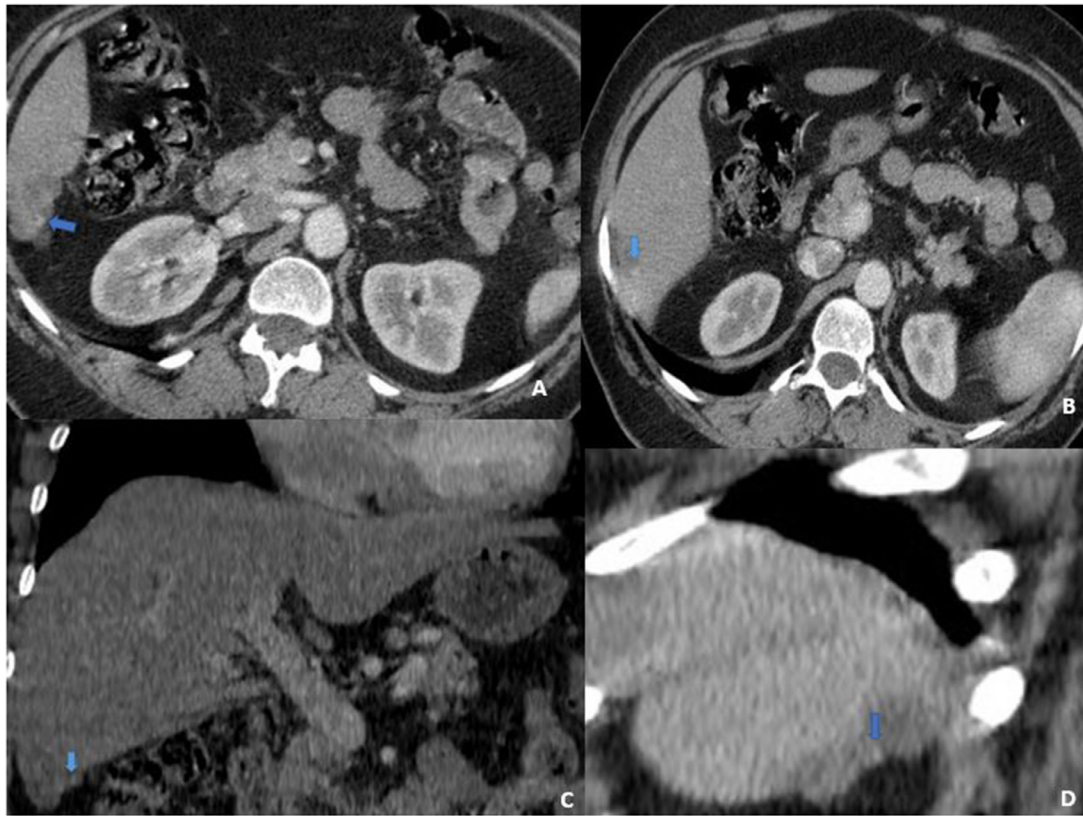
CT scan, axial, coronal, and sagittal plans (A–D) in portal phase shows peripheral nodular enhancement pattern of the subhepatic lesion.
